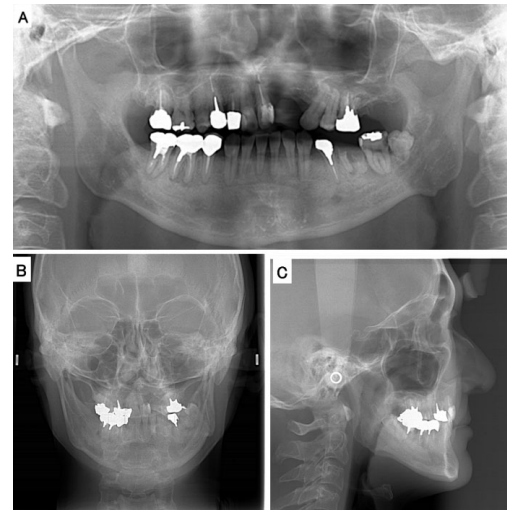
Panoramic radiograph showing the absence of multiple teeth, as well as several teeth with severe caries and periodontitis (A). Frontal (B) and lateral (C) cephalograms showing a maxillary occlusal cant, mandibular deviation to the left side, and maxillo-mandibular retrusion.
